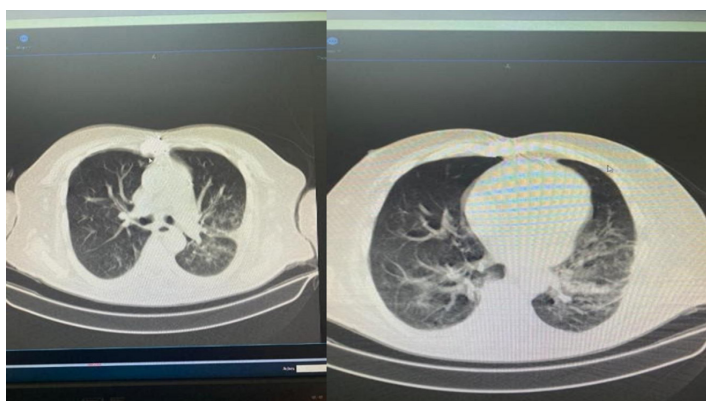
COVID-19 pneumonia in thoracic CT
